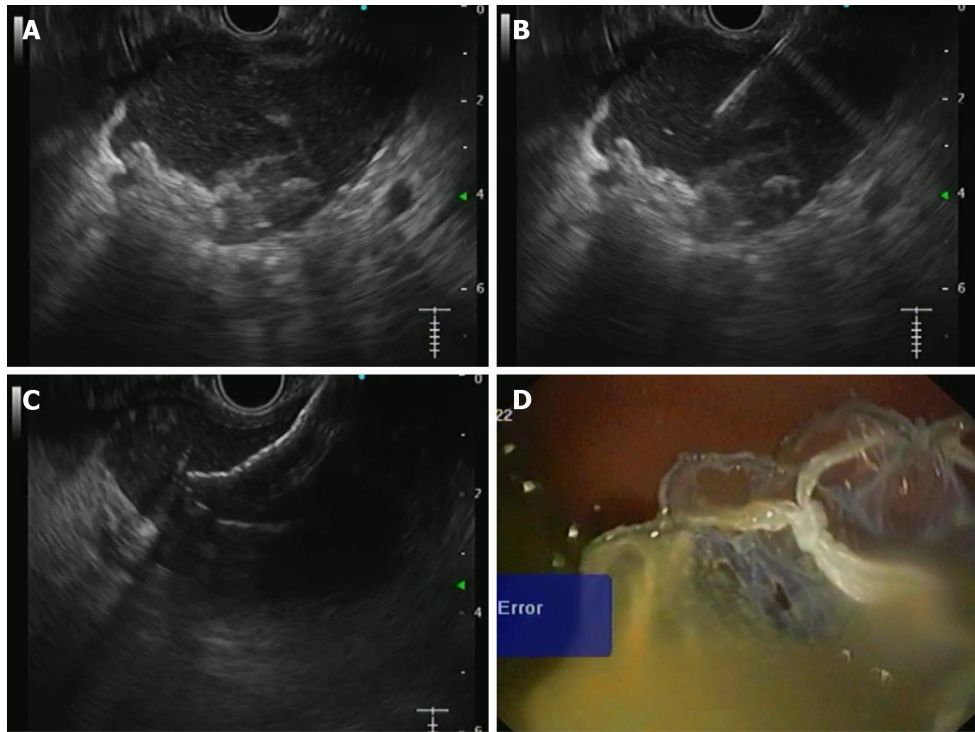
Endoscopy. A: A walled-off collection with hyperechoic necrotic contents; B: The collection was punctured with a 19-gauge needle; C: Proximal flange of the metal stent was deployed under endoscopic ultrasound vision; D: Distal flange of the stent was deployed under endoscopic vision.
